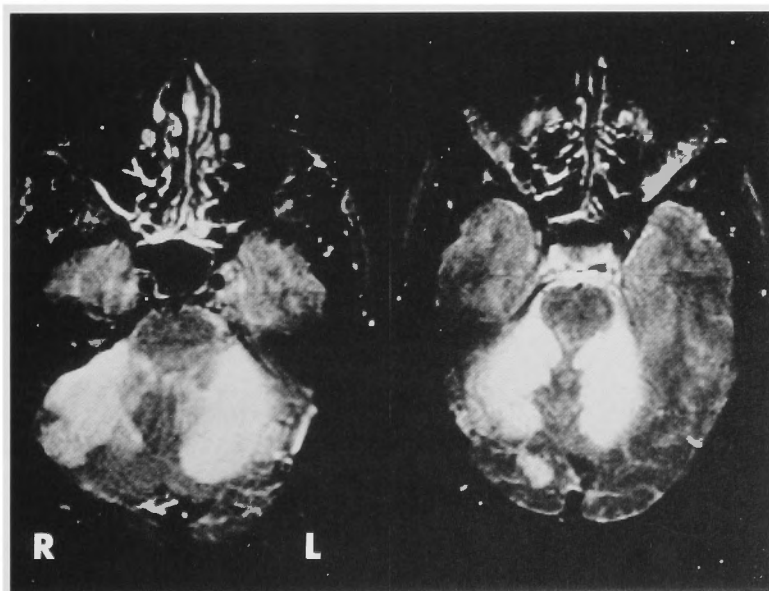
T2-weighted MRI showed a large homogeneous high-intensity area in each cerebellar hemisphere.
